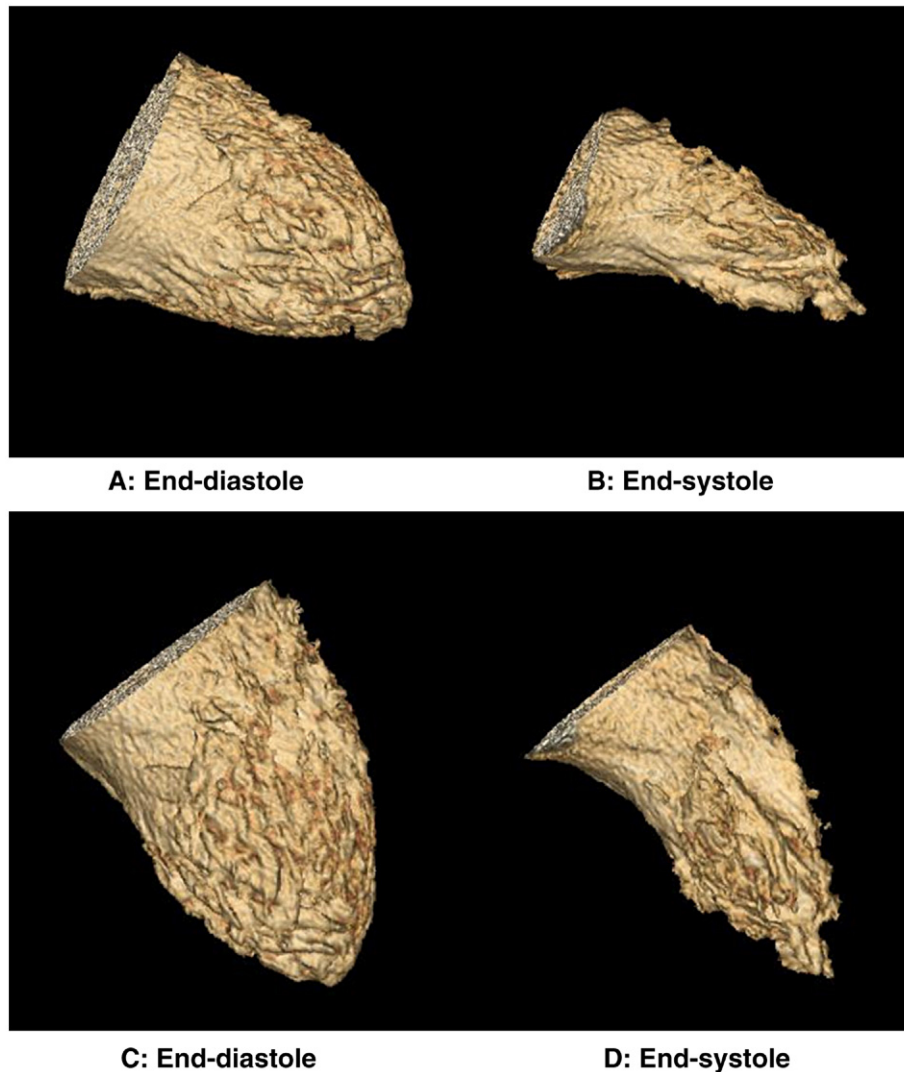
3-dimensional images of the left ventricle (LV) using 64-slice computed tomography (CT), in a normal subject who did not have apical asynergy of LV motion, from the right anterior (A and B) and right superior anterior (C and D) oblique directions, in end-diastole (A and C) and end-systole (B and D). End-diastole volume, end-systole volume, stroke volume and ejection fraction were calculated as 105 mL, 42 mL, 63 mL, and 60%, respectively. In comparison to end-diastole, all LV portions had contracted in end-systole.
